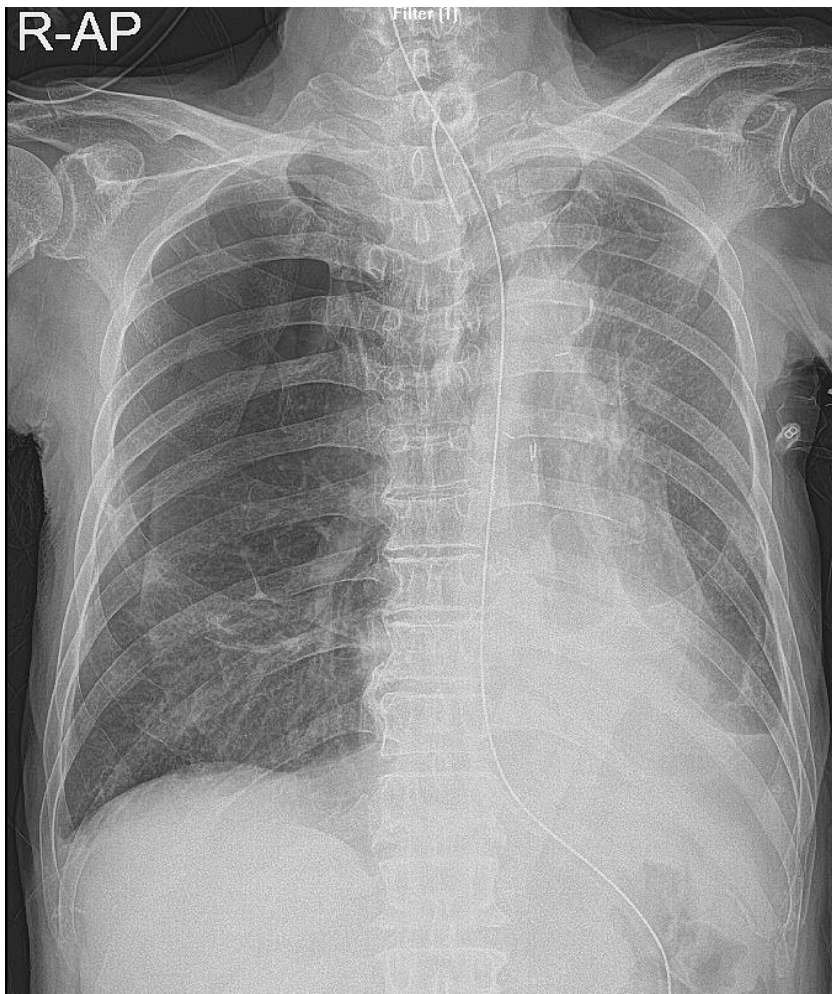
Initial chest x-ray at the time of hospitalization on 18, October, 2018.
